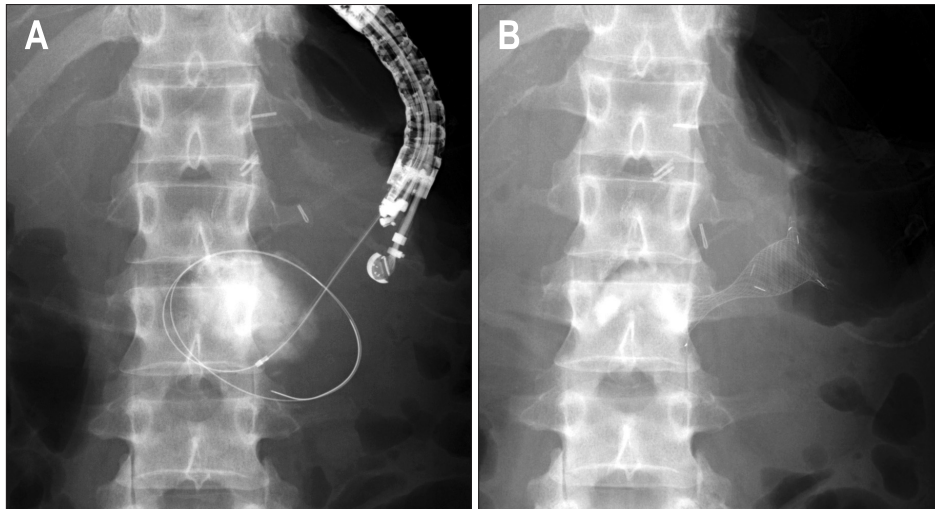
(A) Radiograph showing fistula dilation using a wire-guided 6-Fr diathermic dilator (Cysto-Gastro-Set; Endo-Flex, Voerde, Germany). (B) Radiograph showing the NAGI stent (Taewoong Medical Co., Ltd., Seoul, Korea) into the pancreatic pseudocyst.
